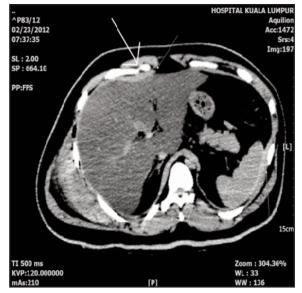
Axial view of plain PMCT scan of a patient showing hyperdense perihepatic and perisplenic haematomas (thin arrows). Right lower rib fracture (thick arrow) detected. CT diagnosis of liver and splenic injuries was made. Subsequent internal conventional autopsy showed the liver and spleen were normal, a false positive finding.
